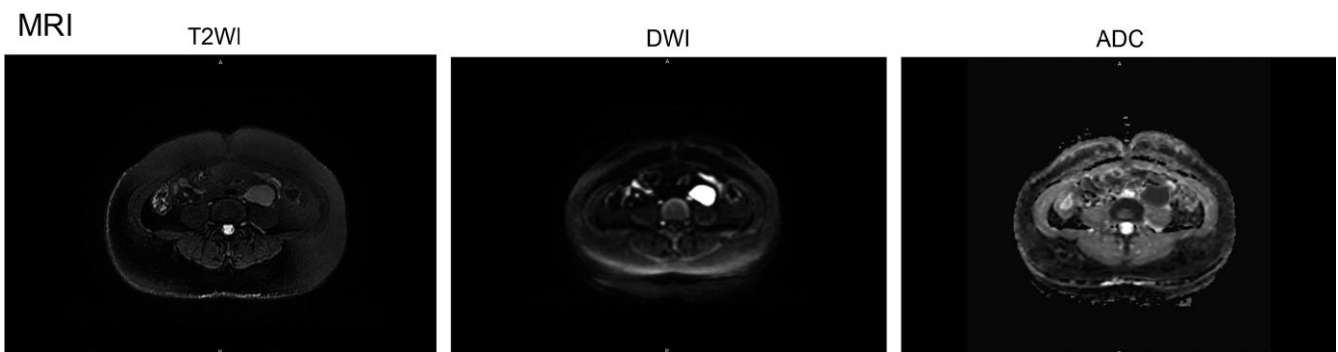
Magnetic resonance imaging (MRI). MRI images indicated a well-defined, oval-shaped mass lesion in the anterior part of the left side psoas muscle with intermediate to high signal intensity on T2 weighted image (T2WI), high signal intensity on diffusion weighted imaging (DWI), and low signal intensity on the apparent diffusion coefficient (ADC) map
